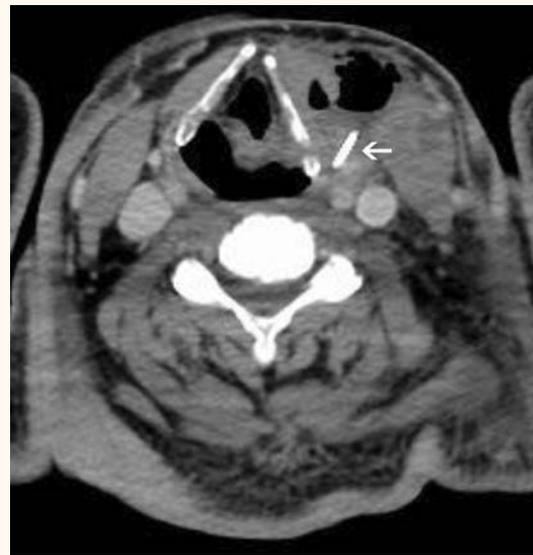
Computed tomography axial scan showing the foreign body in the neck on the left side in close proximity to the carotid arteries (white arrow).
